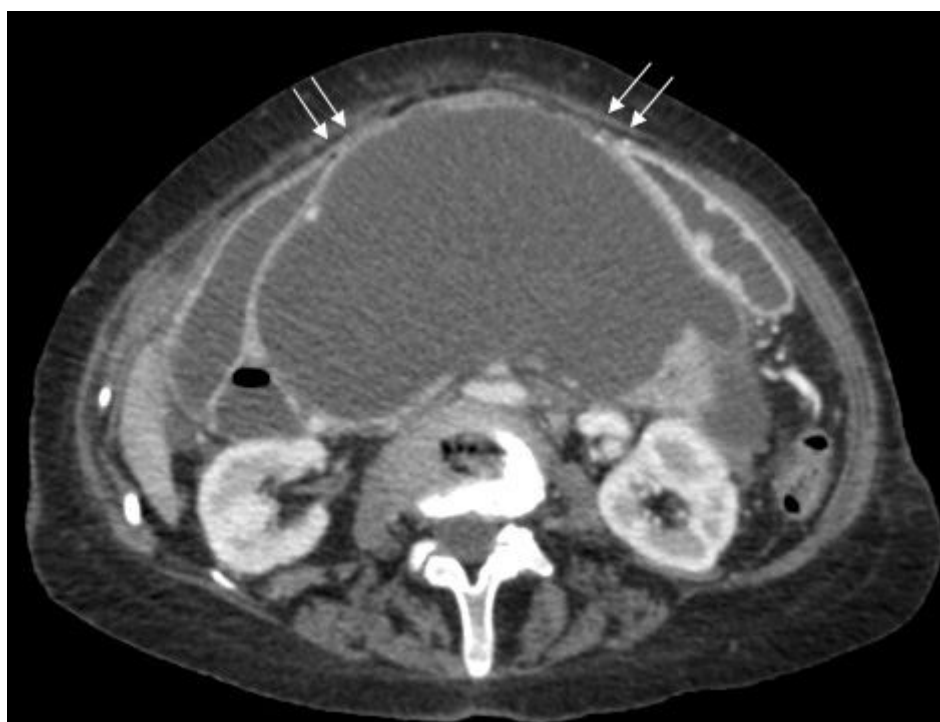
Axial post-contrast computed tomography (CT) scan of the upper abdomen showing a large pancreatic pseudocyst with the stomach (arrows) stretched anteriorly over it.
